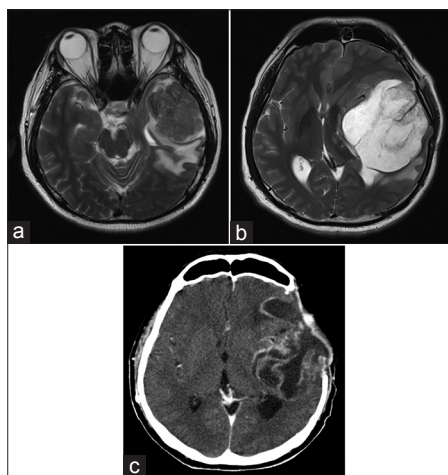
(a) Magnetic resonance imaging scan of the brain showing the initial left temporal mass before surgery. (b) Magnetic resonance imaging of the brain showing tumor recurrence 5 months after initial surgery. (c) Computed tomography of the brain showing tumor recurrence 6 months after diagnosis and after two separate tumor resections
